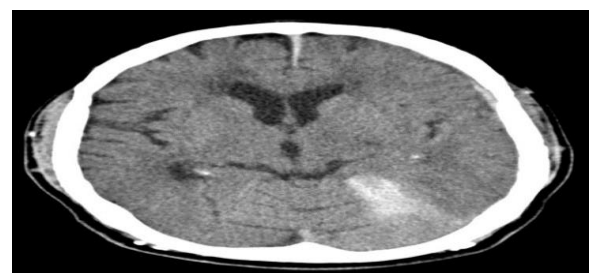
An axial CT scan of the brain shows a hyper-density rear to the left temporal lobe and above the cerebellum.
